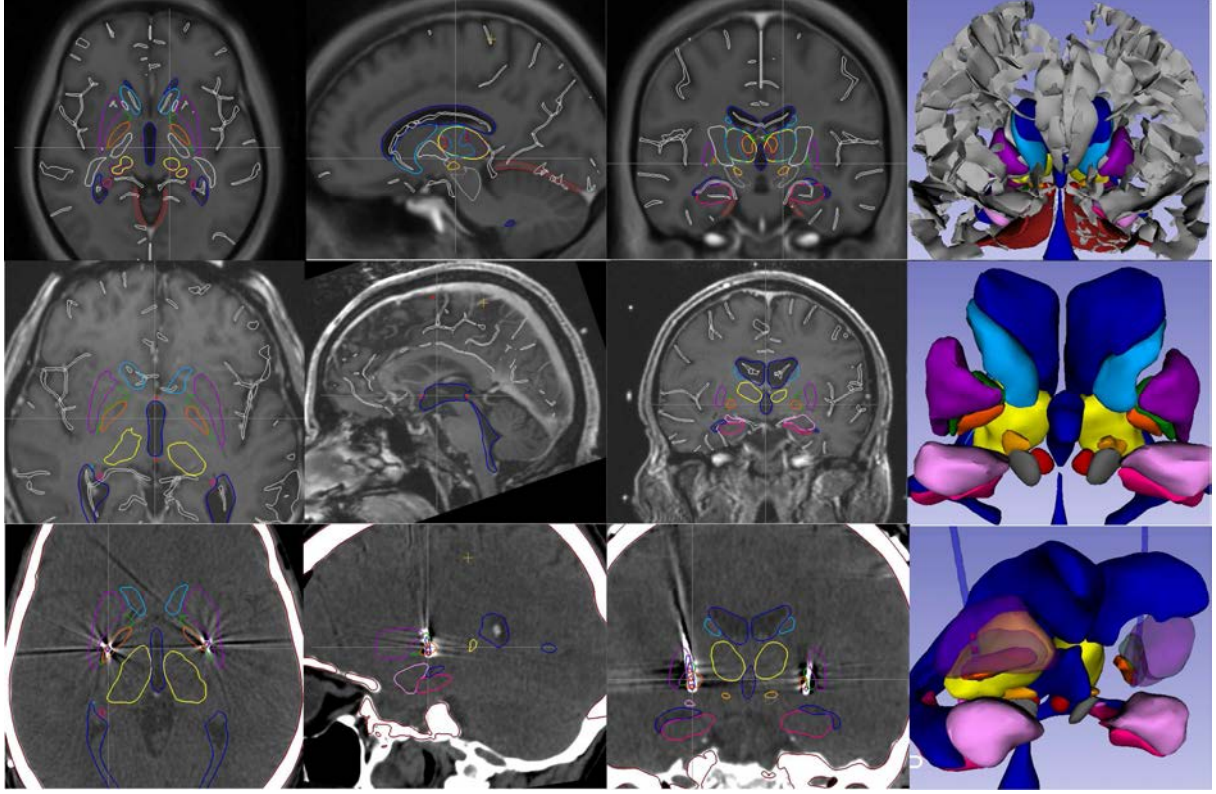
Axial, parasagittal, coronal and 3D views of 1) *first row*, the Parkinson template and the deep brain structure segmentation, 2) *second row*, a patient MRI with the registration of the deep brain structure segmentation on his MRI, and 3) *third row*, the postoperative CT with the registration of the deep brain structure segmentation, showing the location of the bilateral implanted electrodes in the GPm.
